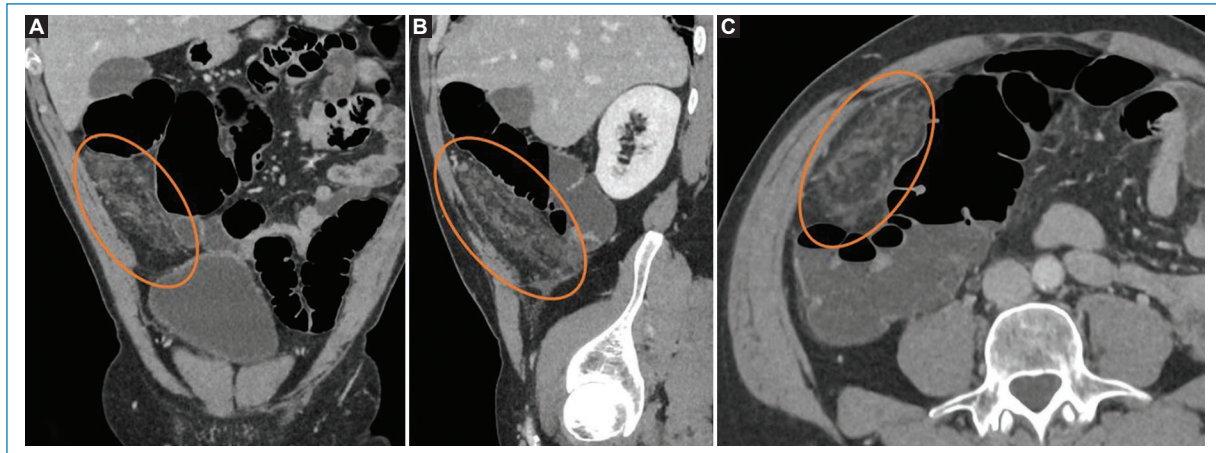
A 53-year-old male, without medical history, who presents for abdominal pain of 8/10 intensity of 24 hrs evolution. On physical examination: soft abdomen in left hemiabdomen, with abdominal guarding in the right iliac fossa and hypogastrium. Computed tomography is requested due to non-visualization of the cecal appendix on ultrasound. A: coronal reconstruction. B: sagittal reconstruction. C: axial slice. Inflammatory involvement in the right iliac fossa-right flank, in contact with the antimesenteric border of the ascending colon wall, pseudo-encapsulated appearance, trabeculated and with mass effect, in relation to omental infarction. No thickening of the colon wall is visible.
